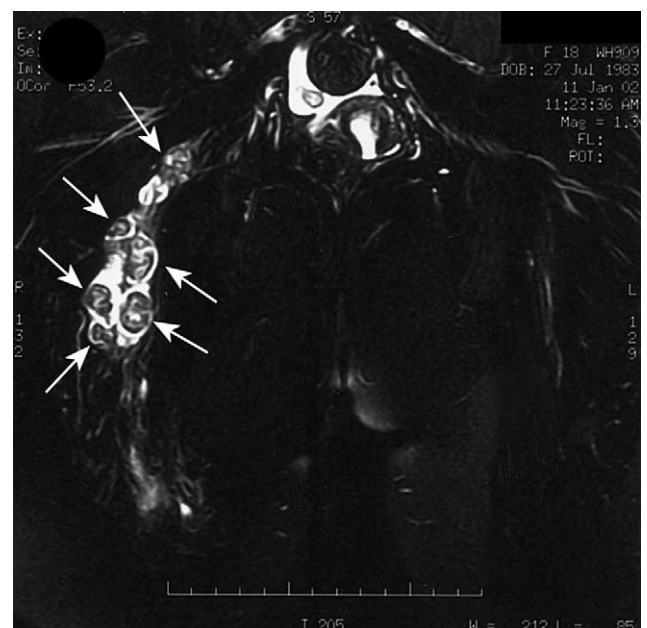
T2WI coronal MRI of the right sciatic nerve: note the multiple lesions.
